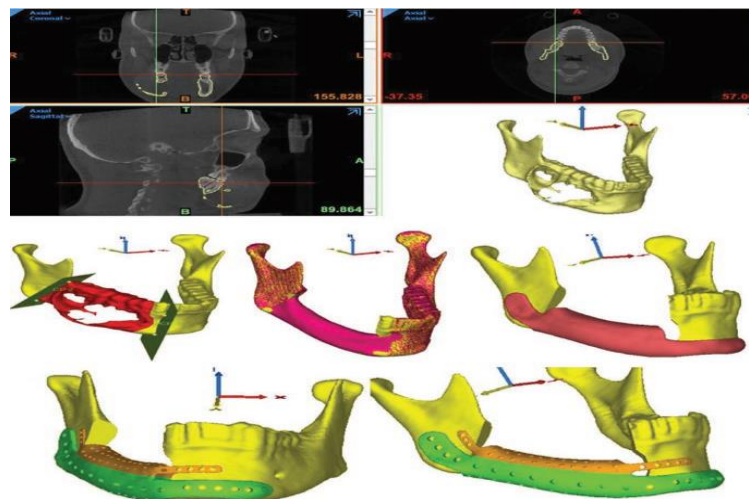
Patient presented with ameloblastoma lesion in the right side of the mandible. (a) The Materialise MIMICS 21.0 software (Materialise NV, Leuven, Belgium) translated the CBCT DICOM data into axial, coronal, and sagittal planes and 3D view. (b) The tumor region was detected, segmented in red, and virtual surgical resection guiding plans were placed anterior and posterior to the lesion borders in the body of mandible. (c) The mandibular bone defect was reconstructed by mirroring the normal mandibular body on the left side, and (d) the prosthesis was designed based on the remaining mandibular bone. (e) The final prosthesis design was divided into two porous sections (25).
